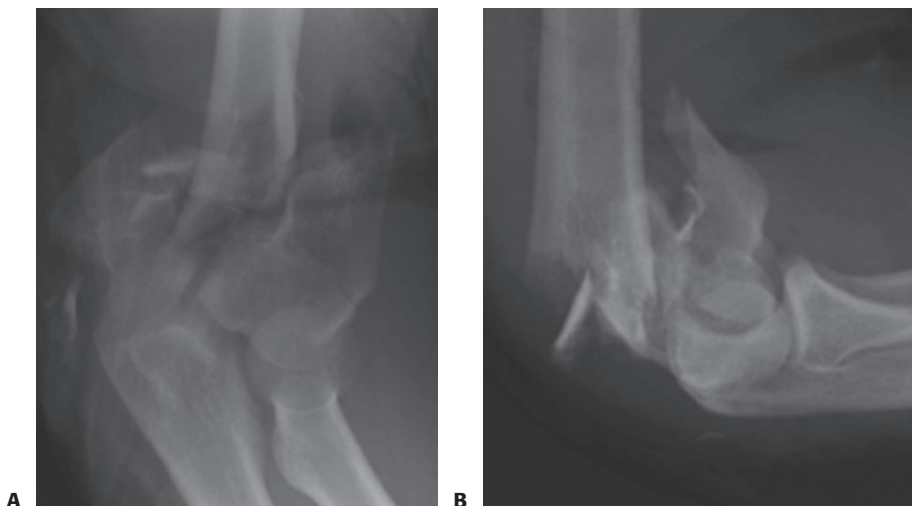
• Standard AP (A) and lateral (B) plain radiographs.
